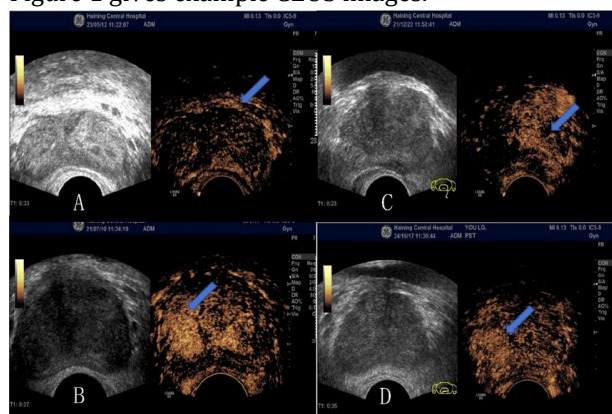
Representative conventional transrectal ultrasound and contrast-enhanced ultrasound images of malignant and benign prostatic lesions. (A, B) Prostate cancer showing rapid and marked arterial-phase hyperenhancement. (C) Prostatitis showing focal rapid arterial-phase hyperenhancement. (D) Benign prostatic lesion showing focal rapid arterial-phase hyperenhancement. Left images are conventional ultrasound; right images are contrast-enhanced ultrasound. Arrows indicate the target lesions or regions of interest.
